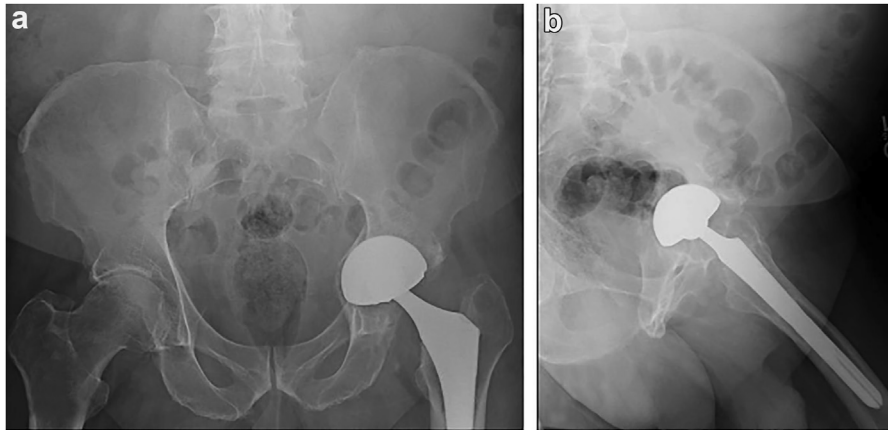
(a and b) Anteroposterior and cross-table lateral radiographs performed at our institution roughly 2 years and 1 month following initial arthroplasty demonstrating medialization of the acetabular component beyond the medial wall of the acetabulum without evidence of liner malseating on the lateral radiograph.
